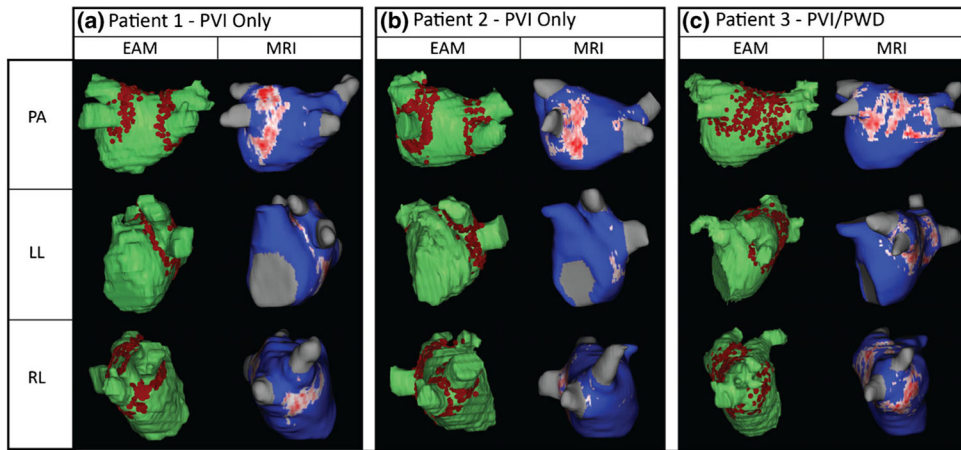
a–c Comparison of ablated area marked on EAM (*left column*) and scar on LGE-MRI (*right column*) depicting poor and inconsistent scar formation in three patients. *EAM* electroanatomic mapping, *LGE-MRI* late-gadolinium enhancement magnetic resonance imaging, *PVI* pulmonary vein isolation, *PWD* posterior wall debulking
